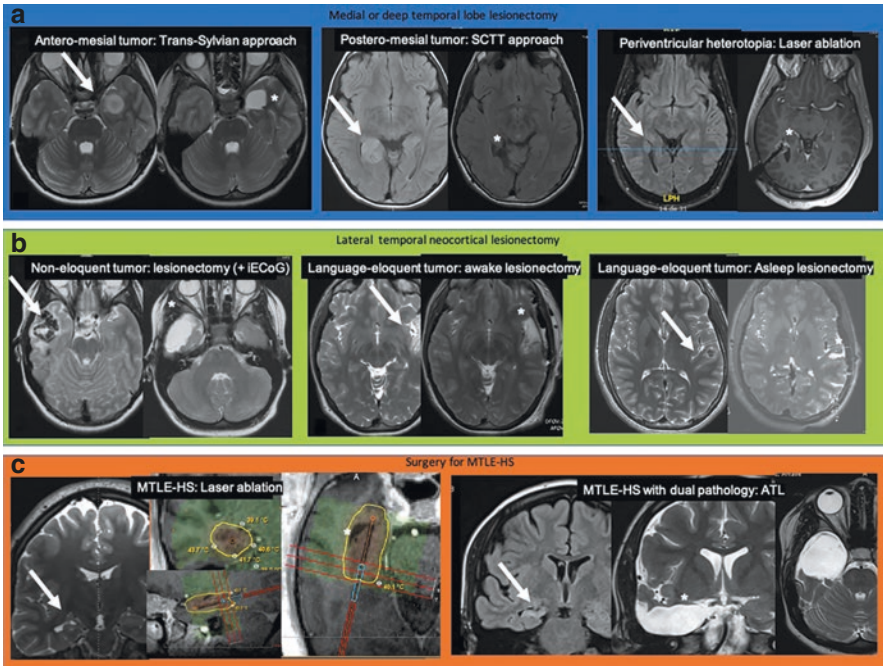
Non-exhaustive portrait of 8 lesional TLE cases and various surgical approaches. MRI showing the lesion (arrow) and postoperative resection cavity (asterix). Left anterior peri-amygdala tumor resected through a trans-Sylvian approach (a); right postero-medial tumor resected through a SCTT approach (b); right periventricular heterotopia treated with LITT (c); right-hemisphere non-eloquent calcified DNET treated with lesionectomy using intra-operative ECoG which did not reveal additional interictal spiking (d); language-eloquent left temporal DNET that underwent lesionectomy under awake craniotomy (e); language-eloquent left temporal DNET resected under asleep craniotomy (f); MTLE-HS treated with LITT (g); MTLE-HS and lateral involvement on PET (dual pathology with subtle FCD) treated with ATL (h)
